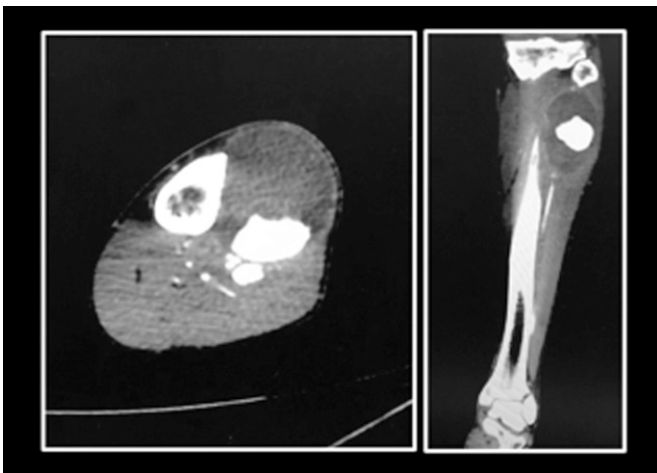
CT scan demonstrating large pseudoaneurysm in the proximal portion of the anterior tibial artery; pseudoaneurysms in this location are infrequent and often secondary or iatrogenic cause.
